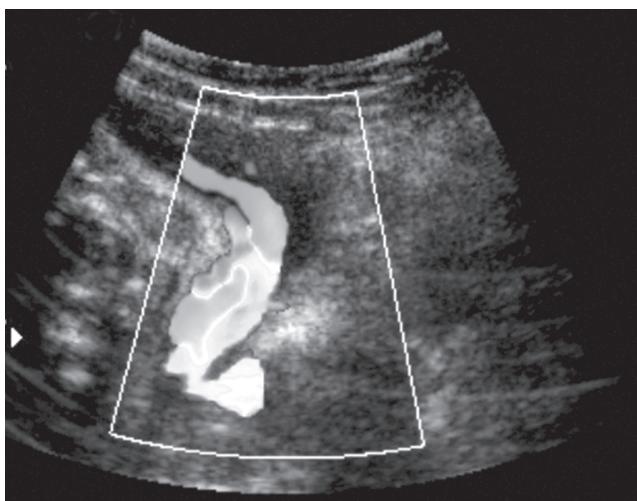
Color Doppler of umbilical cord
